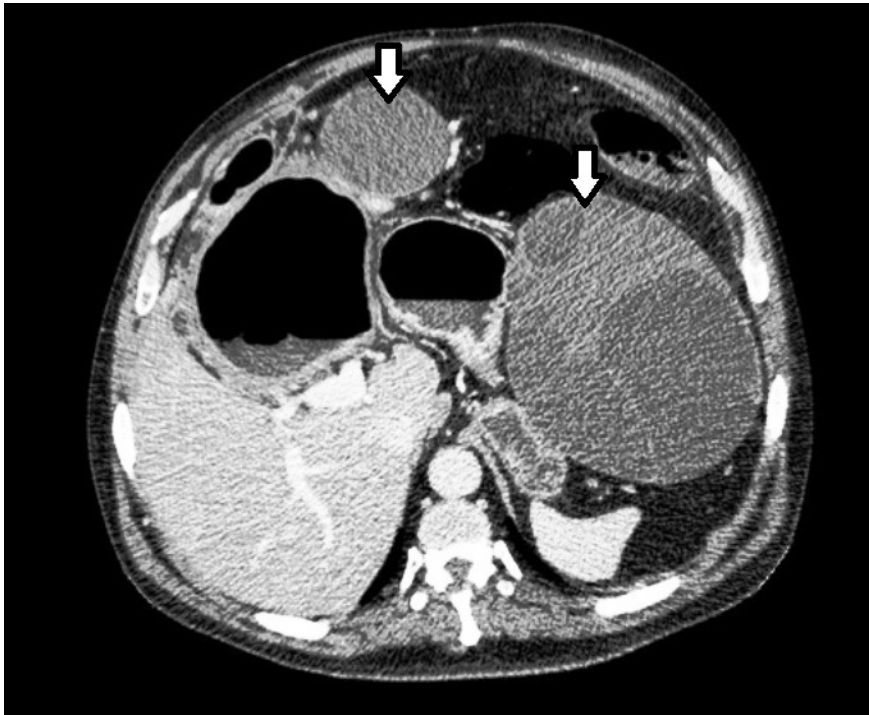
Computed tomography scan demonstrating the presence of peritoneal unenhanced hypoattenuating cystic masses with well-defined borders and partially calcified wall (arrows).
